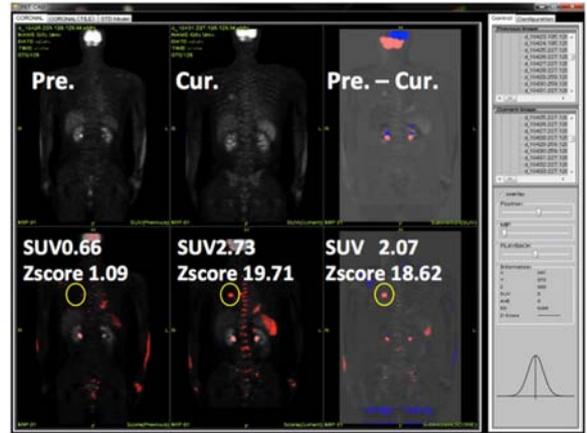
Interface of temporal subtraction system for FDG-PET scans.
